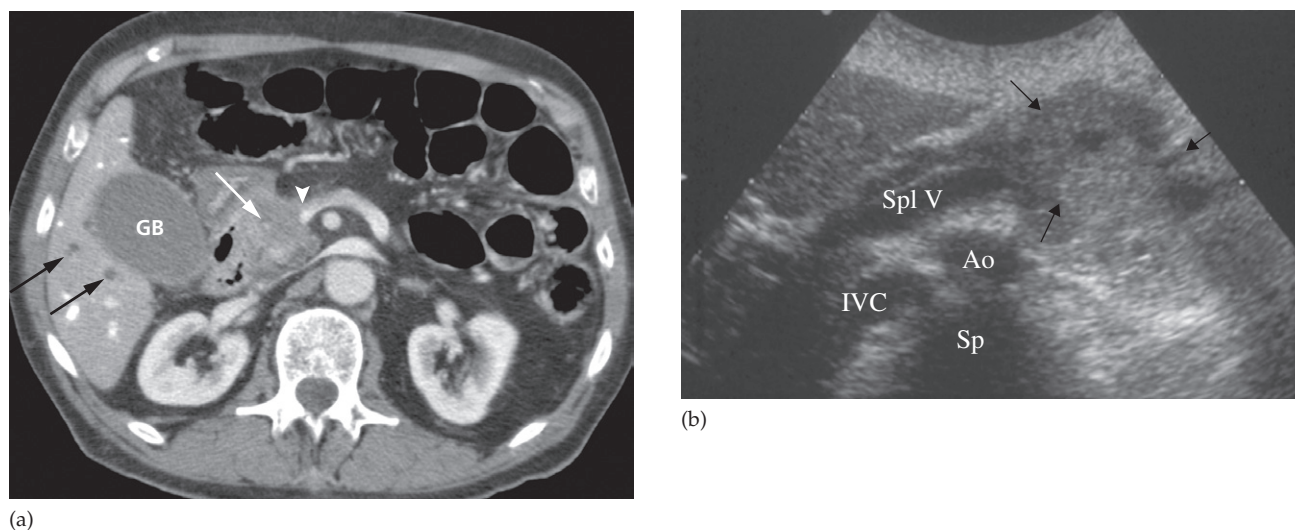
Carcinoma of the pancreas. (a) CT scan showing a focal mass in the head of the pancreas (white arrow), which involves the portal/mesenteric vein confluence (arrow head) and may preclude curative surgery (compare with the endoscopic ultrasound image, Fig. 7.34, performed in the same patient). Note the dilated intrahepatic bile ducts (black arrows) and distended gall bladder (GB). (b) Transverse ultrasound scan showing a large mass in the body of the pancreas (arrows). Ao, aorta; IVC, inferior vena cava; Sp, spine; Spl V, splenic vein.
